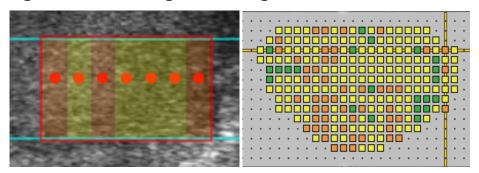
Tissue change monitoring on ultrasound.
